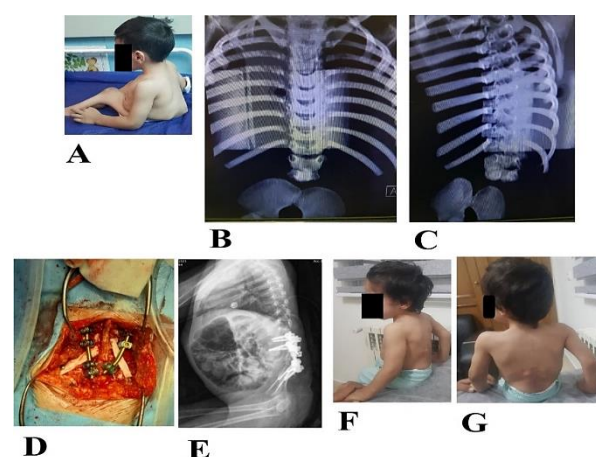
A) Preoperative photograph of the patient that shows severe thoracolumbar (TL) kyphosis and knee webbing; B, C) Anteroposterior (AP) and lateral radiographies consistent with type IV Renshaw sacral agenesis (SA); D) The surgical instrumented fusion with fibular allograft; E) Postoperative radiography; F, G) Postoperative photograph
